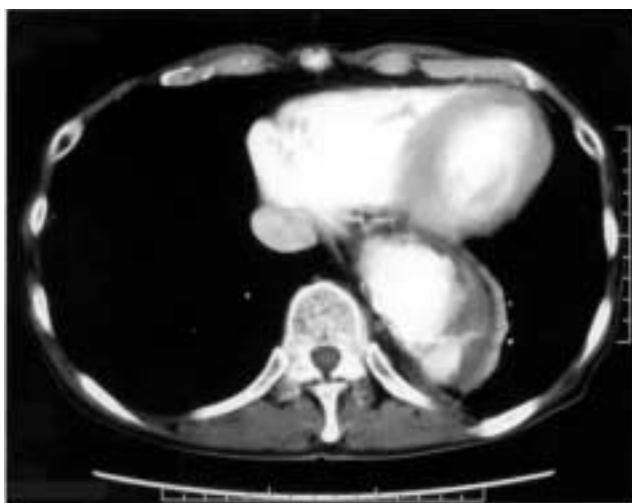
Computed tomography demonstrating an aneurysm of the descending aorta, with a dilatation 6 cm in diameter.
